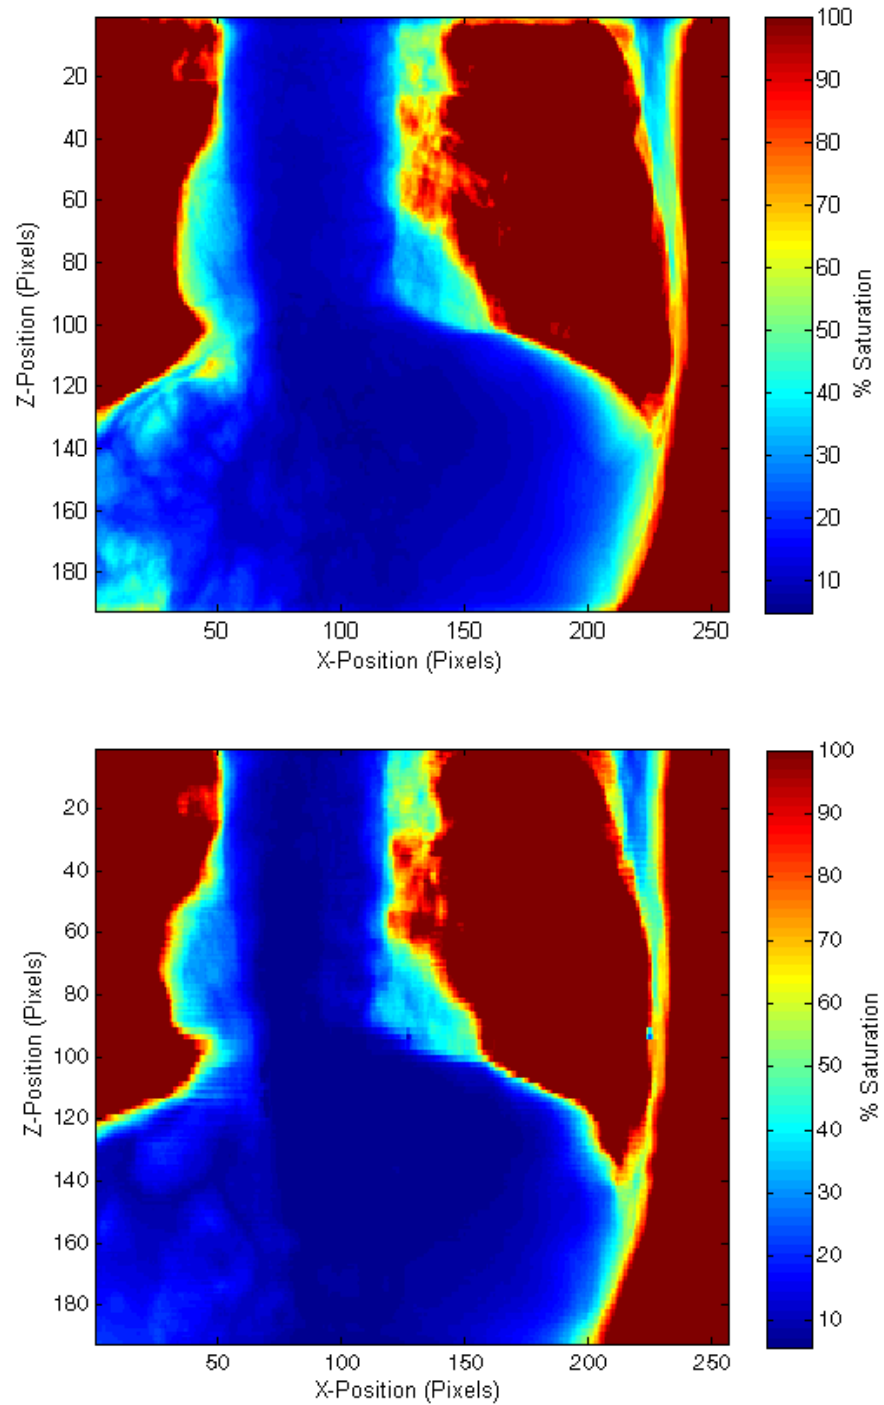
Esophagus radiograph of a patient acquired at 120 kVp and 8 mAs. The top image was taken of the patient during a fraction of IGRT and the bottom image was calculated by the DRR software.
